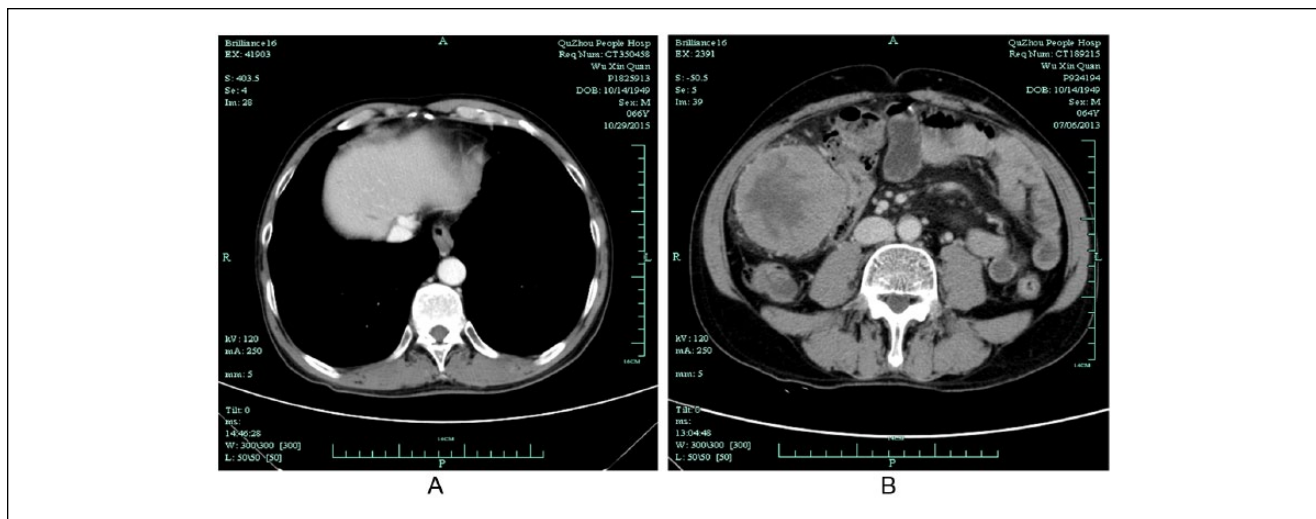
Computed tomography scan of liver and abdomen with 2 years of TCM treatment on October 29, 2015. (A) CT showed tumor in the liver disappeared. (B) Omentum metastasis in the abdomen vanished.
